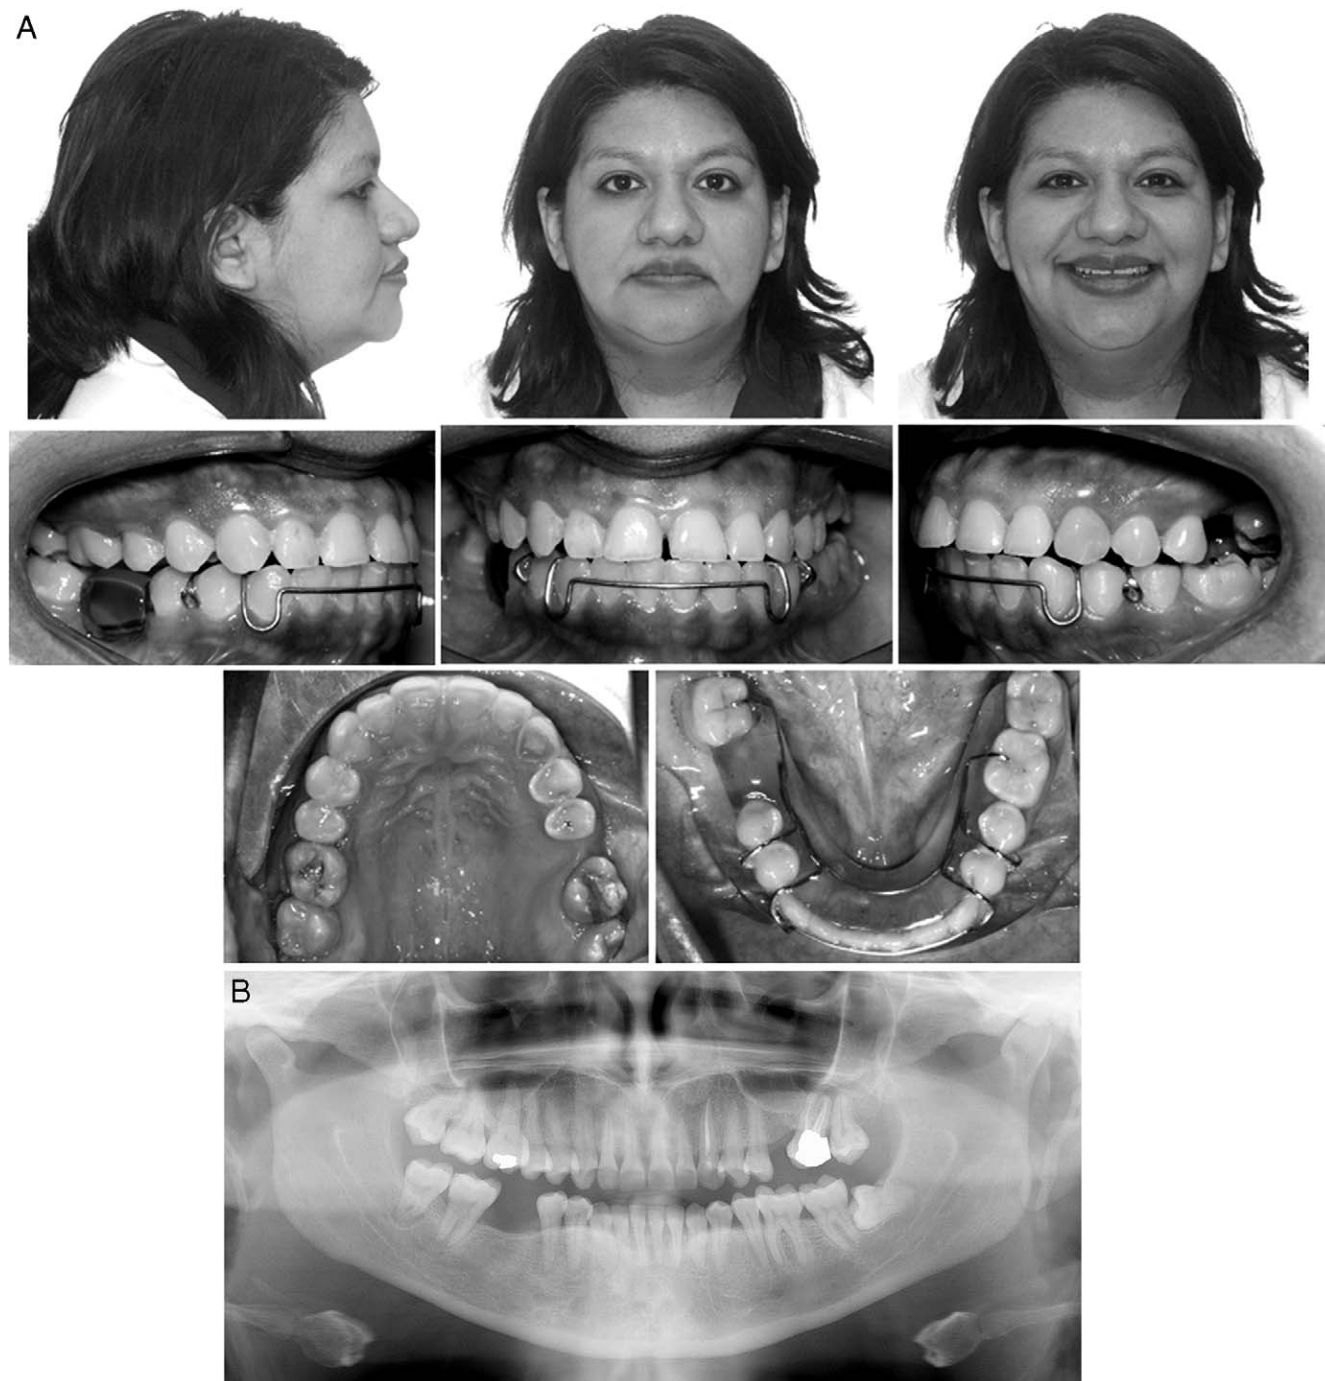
(A) Posttreatment photographs and lower Hawley. (B) Posttreatment panoramic radiograph.
